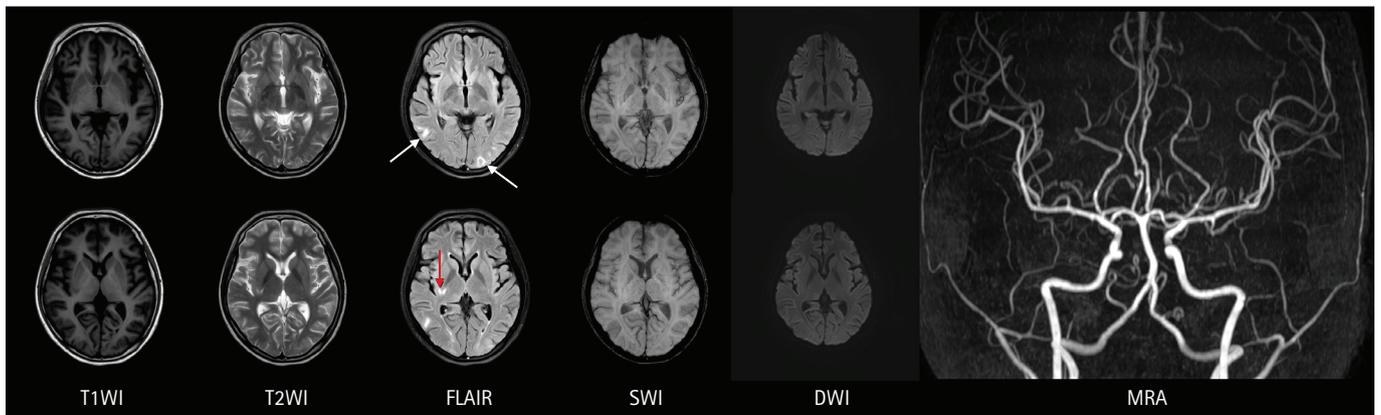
Brain magnetic resonance imaging after intravenous methylprednisolone and immunoglobulin treatment. Fluid-attenuated inversion recovery (FLAIR) image revealed possible posterior reversible encephalopathy syndrome (white arrows) and possible lupus cerebritis in the right basal ganglia region (red arrow). Diffusion weighted imaging (DWI), susceptibility-weighted imaging (SWI), and time-of-flight magnetic resonance angiography (MRA) showed no evidence of ischemic and hemorrhagic vascular lesions.
